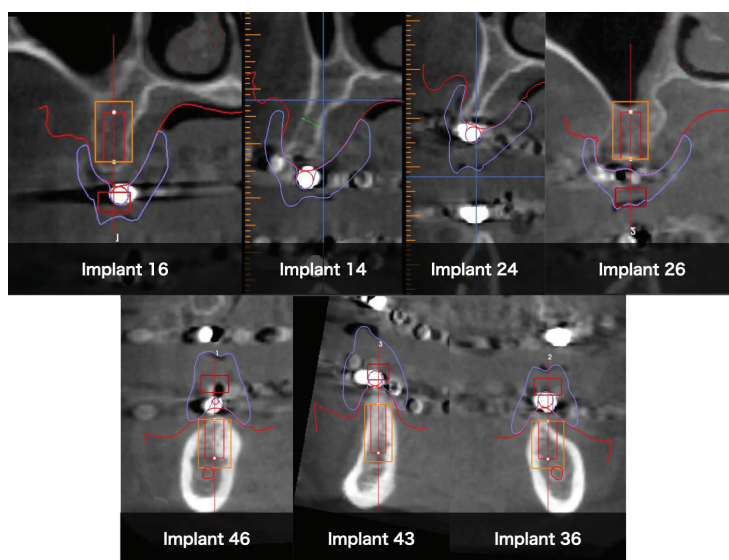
Cone-beam computed tomography images of implants 14, 16, 24, 26, 36, 43, and 46.
